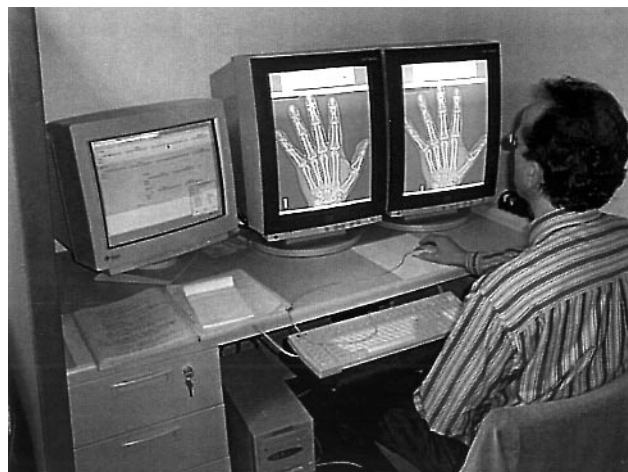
Digital radiographic reading station. Serially acquired digitized radiographs are viewed side by side following edge enhancement and magnification. Reading results are registered on an electronic score sheet (left screen) and automatically stored in a database.
